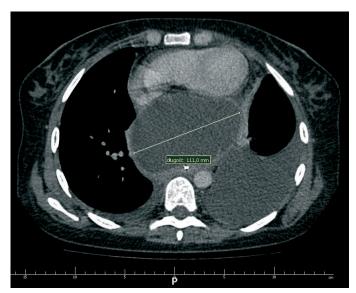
Chest CE-CT: large mediastinal pancreatic pseudocyst.
